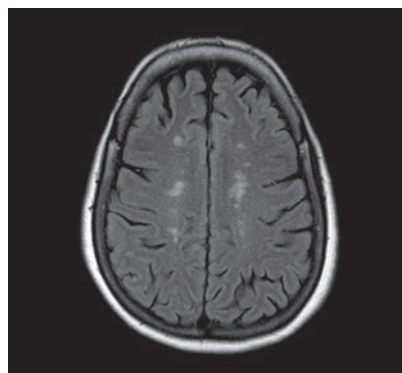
FLAIR image showing periventricular white matter lesions.
